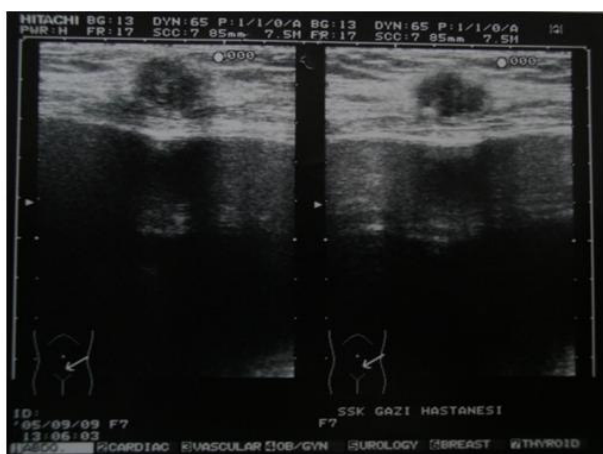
The abdominal ultrasound of incisional endometriosis on pfannenstiel incision of the patient.
